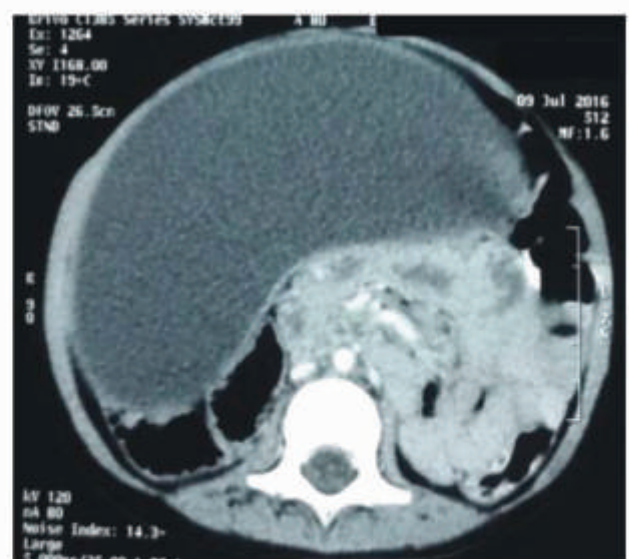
CT Scan showing bulky heterogeneous pancreas with large smooth, enhancing, cystic SOL in upper abdomen, with mass effects
